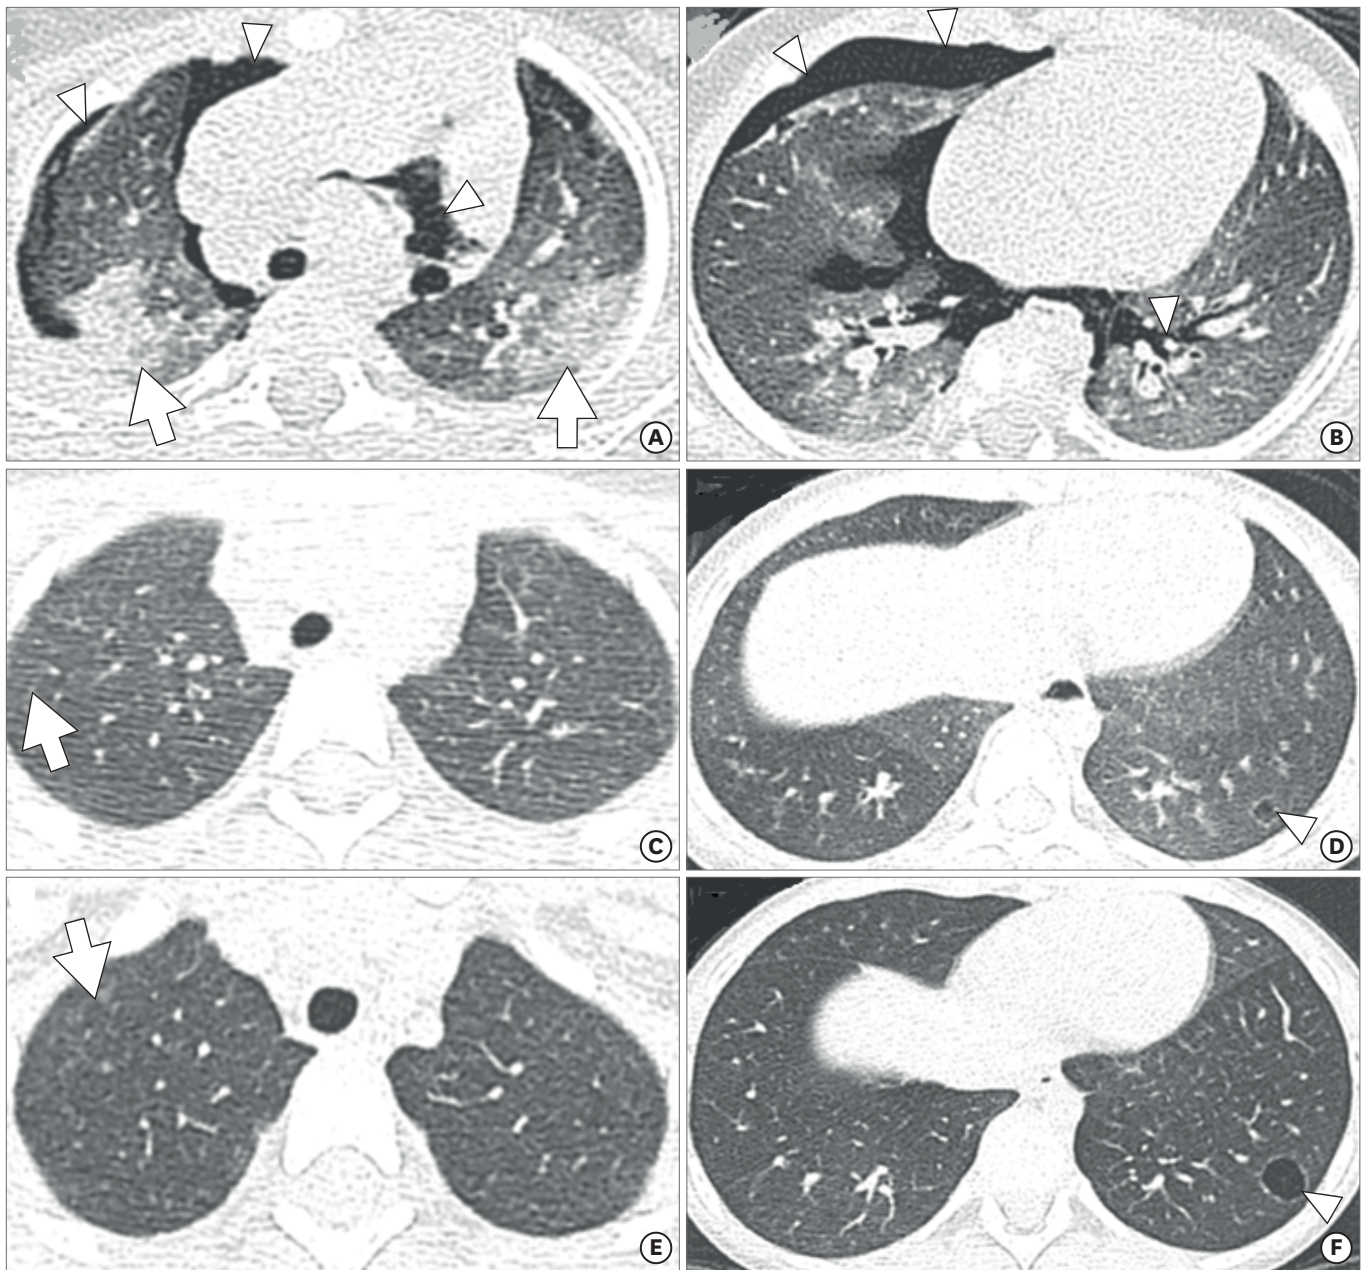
Chest radiography and computed tomography (CT) of case 1. (A, B) At 6 months of age, initial chest CT (1-mm-thick axial images) showed extensive air leakage (arrowheads) indicating pneumothorax, pneumomediastinum, and pulmonary interstitial emphysema. Patchy consolidations (arrows) and ill-defined ground-glass opacities are also noted. (C, D) After 3 years, larger, subtle ground-glass opacities with air trapping, suspicious ill-defined centrilobular nodules (arrow), and a small air cyst (arrowhead) remained. (E, F) At 5 years of age, multiple tiny and faint centrilobular nodules (arrow) in both lungs and a small air cyst (arrowhead), possibly a pneumatocele, remained in the basal segment of the left lower lobe.
